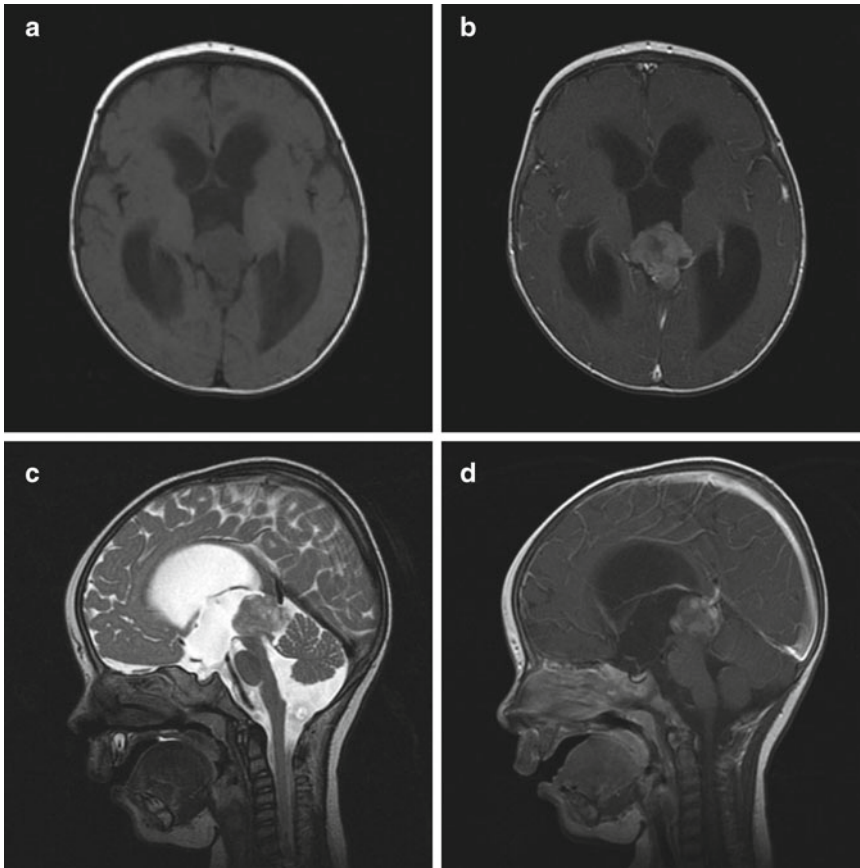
Magnetic resonance imaging of pineoblastoma. *Upper panel:* Axial T1-weighted MRI images before (a) and after (b) gadolinium administration. *Lower panel:*
